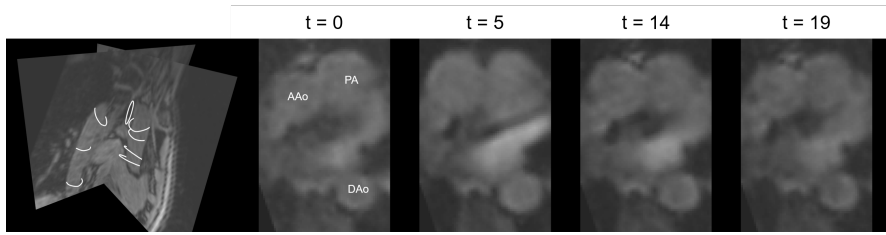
(Left) Typical distribution of manual contours in 3D PC-MRI magnitude data. Eight evaluation points from ascending aorta through descending aorta were defined for evaluating algorithm performance. (Right) Sample 2D reformatted slice at five time points to show image quality given with low contrast between AAO and PA. AAO = ascending aorta; DAAo = descending aorta. PA = pulmonary artery.
